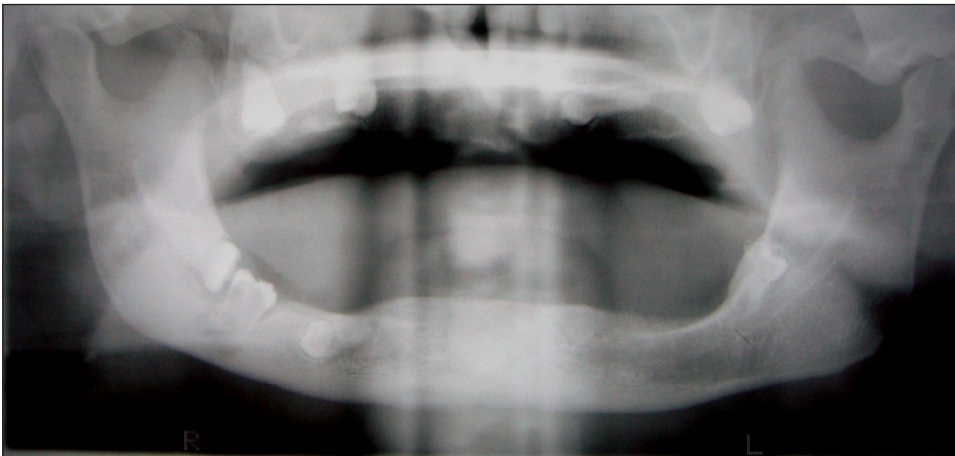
Panoramic radiograph showing eight impacted teeth, four in the maxilla and four in the mandible.
